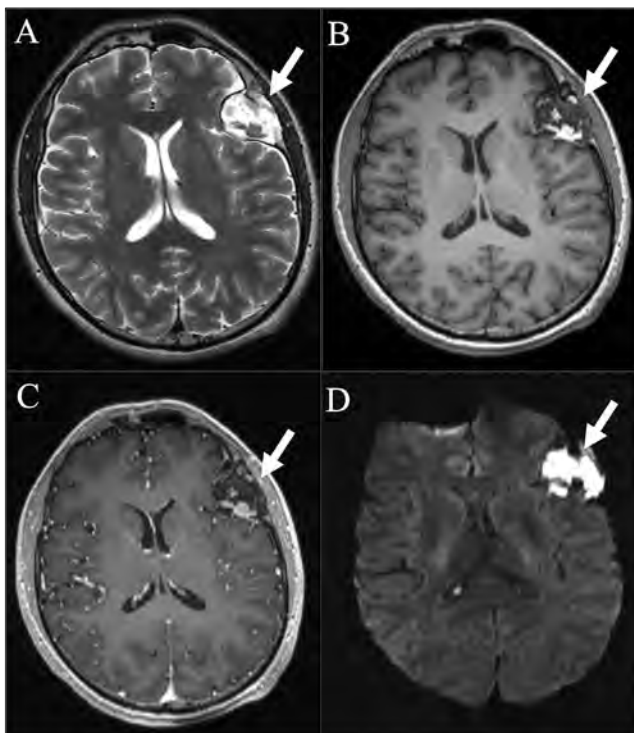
Pathologically proven epidermoid in a 34-year-old male. (A) Axial T2WI and (B) axial T1WI show a mixed-intensity but predominantly T2 hyperintense and T1 hypointense expansile lesion (arrows) with intrinsic T1 hyperintense and T2 hypointense foci, likely representing high proteinaceous or hemorrhagic content. (C) Post-contrast T1WI shows no appreciable enhancement within the lesion. (D) DWI reveals hyperintense signal within the lesion (arrow), which represents a combination of diffusion restriction and T2 shine-through.
